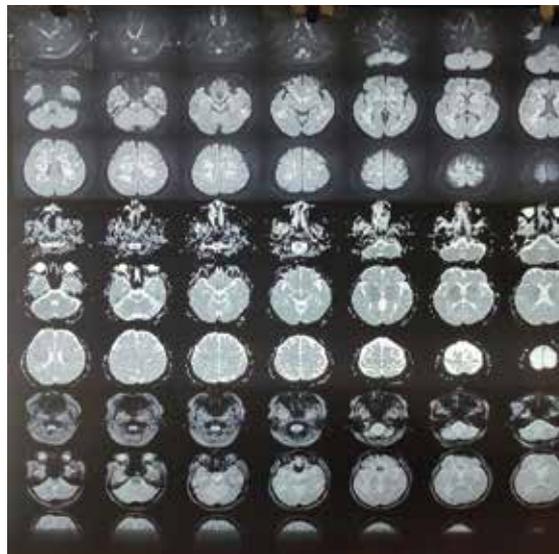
Brain MRI scans showing numerous Tuberculomas of variable size in cerebrum, cerebellum, corpus callosum and brainstem.
